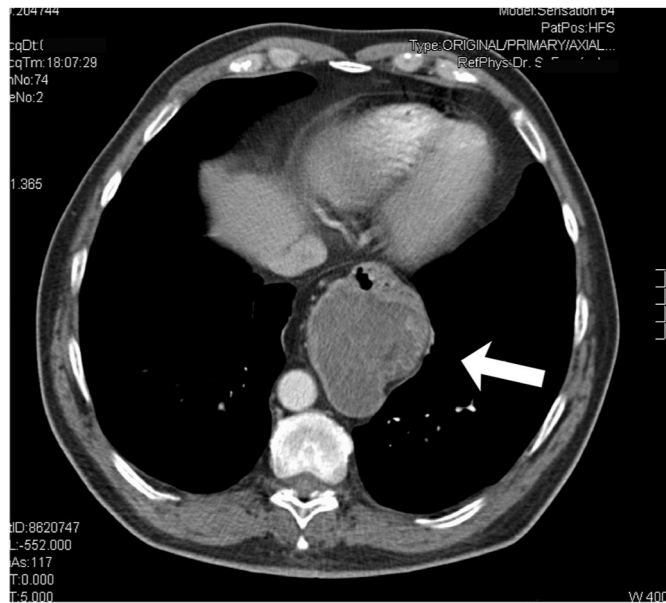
CT showing the paraesophageal hernia, axial section.
